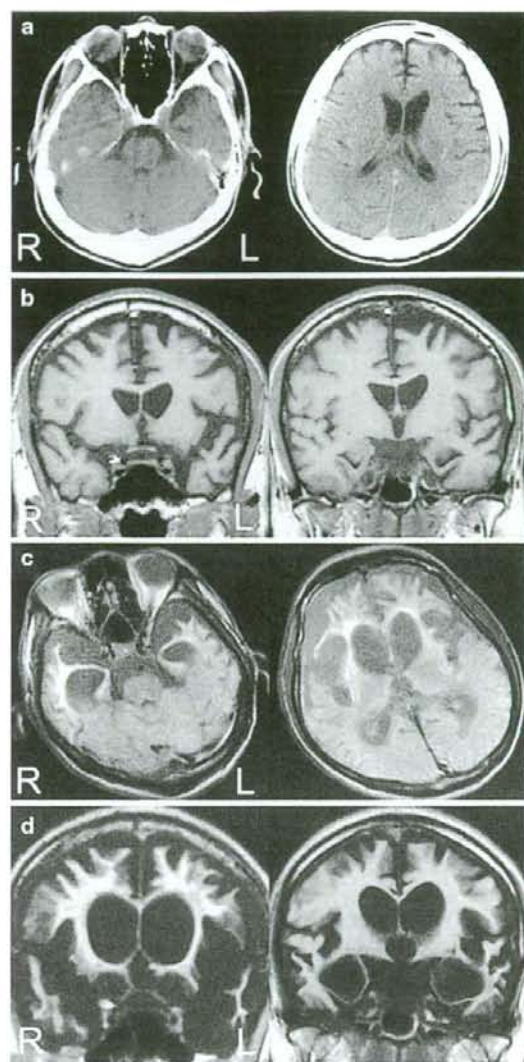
Serial structural radiographic images of BIBD (case 4). Mild, but not negligible, atrophy in the frontal and temporal lobes and caudate nucleus is seen 2 years after the onset (a, b). The cortical atrophy is prominent in the frontal convexity and left superior temporal gyrus, and the temporal base is well spared at this time (b). Fluid attenuated inversion recovery (FLAIR) images 4 years after onset show severe atrophy in the basal ganglia including the caudate nucleus, frontal convexity, and temporal lobes (c, d)
